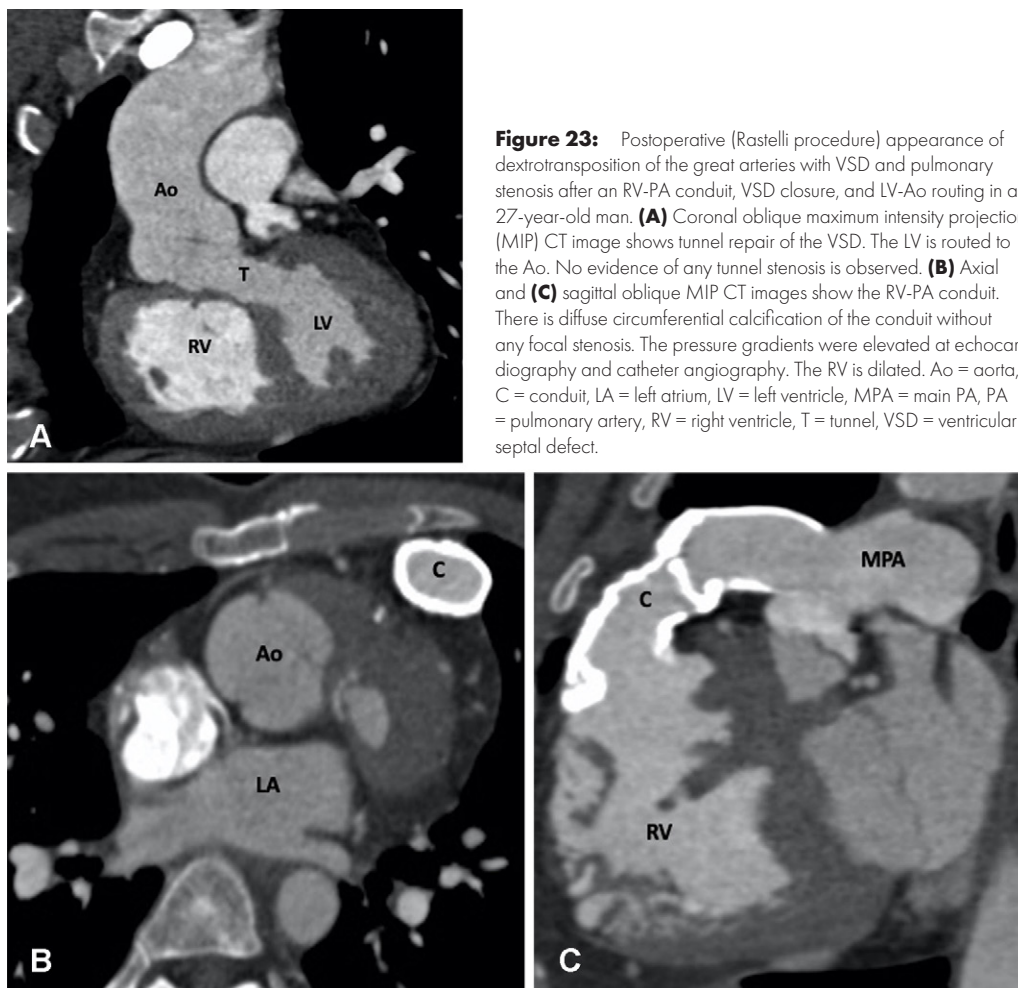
Postoperative (Rastelli procedure) appearance of dextrotransposition of the great arteries with VSD and pulmonary stenosis after an RV-PA conduit, VSD closure, and LV-Ao routing in a 27-year-old man. (A) Coronal oblique maximum intensity projection (MIP) CT image shows tunnel repair of the VSD. The LV is routed to the Ao. No evidence of any tunnel stenosis is observed. (B) Axial and (C) sagittal oblique MIP CT images show the RV-PA conduit. There is diffuse circumferential calcification of the conduit without any focal stenosis. The pressure gradients were elevated at echocardiography and catheter angiography. The RV is dilated. Ao = aorta, C = conduit, LA = left atrium, LV = left ventricle, MPA = main PA, PA = pulmonary artery, RV = right ventricle, T = tunnel, VSD = ventricular septal defect.
